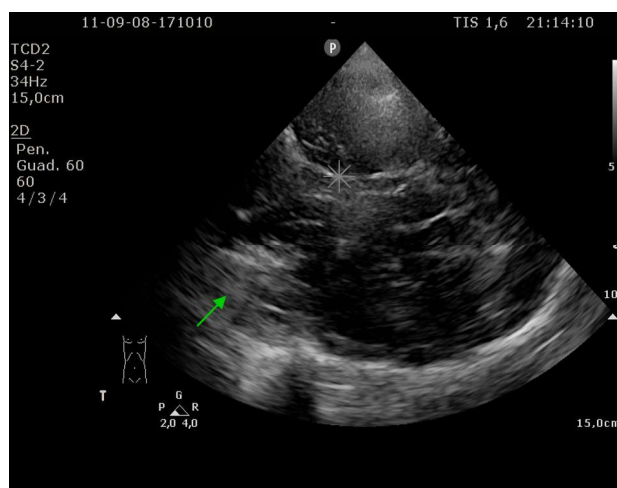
Transcranial sonography using the transtemporal window shows a temporal intracerebral bleed. (* sphenoid wing; Green arrow: intracerebral bleed)
